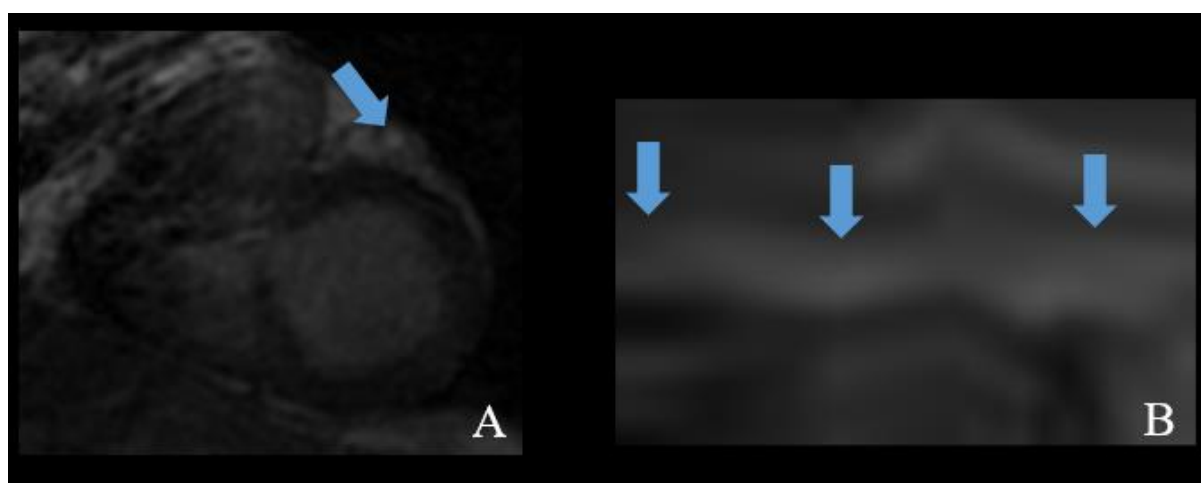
Cardiac MR images acquired with 3T PET/MR using 3D HEART sequence (A: short axial view, arrow indicates a coronary vessel, B: a curved plane view of the coronary vessel was reconstructed by tracking the centre of the vessel)
